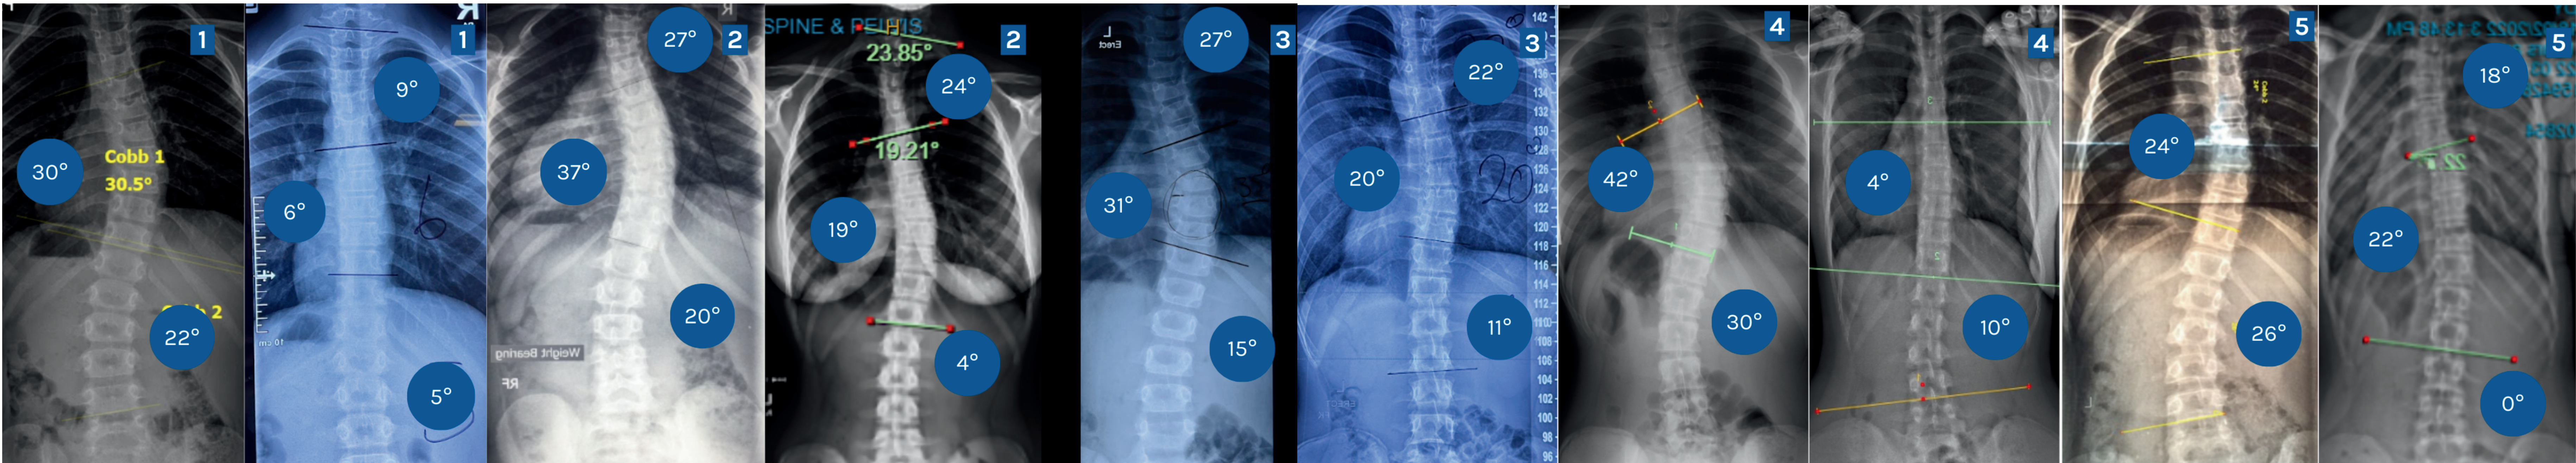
Pre (left) and post (right) X-ray images of all five case studies
